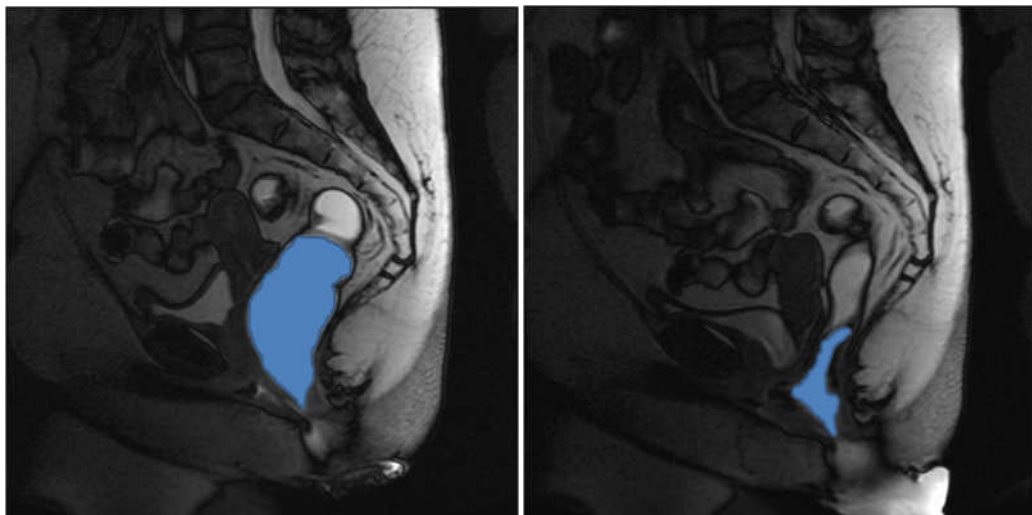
MR images showing the shadow of contrast below the first mucosal fold at the beginning and end of evacuation (before SNS: a and b; and after SNS: c and d)
